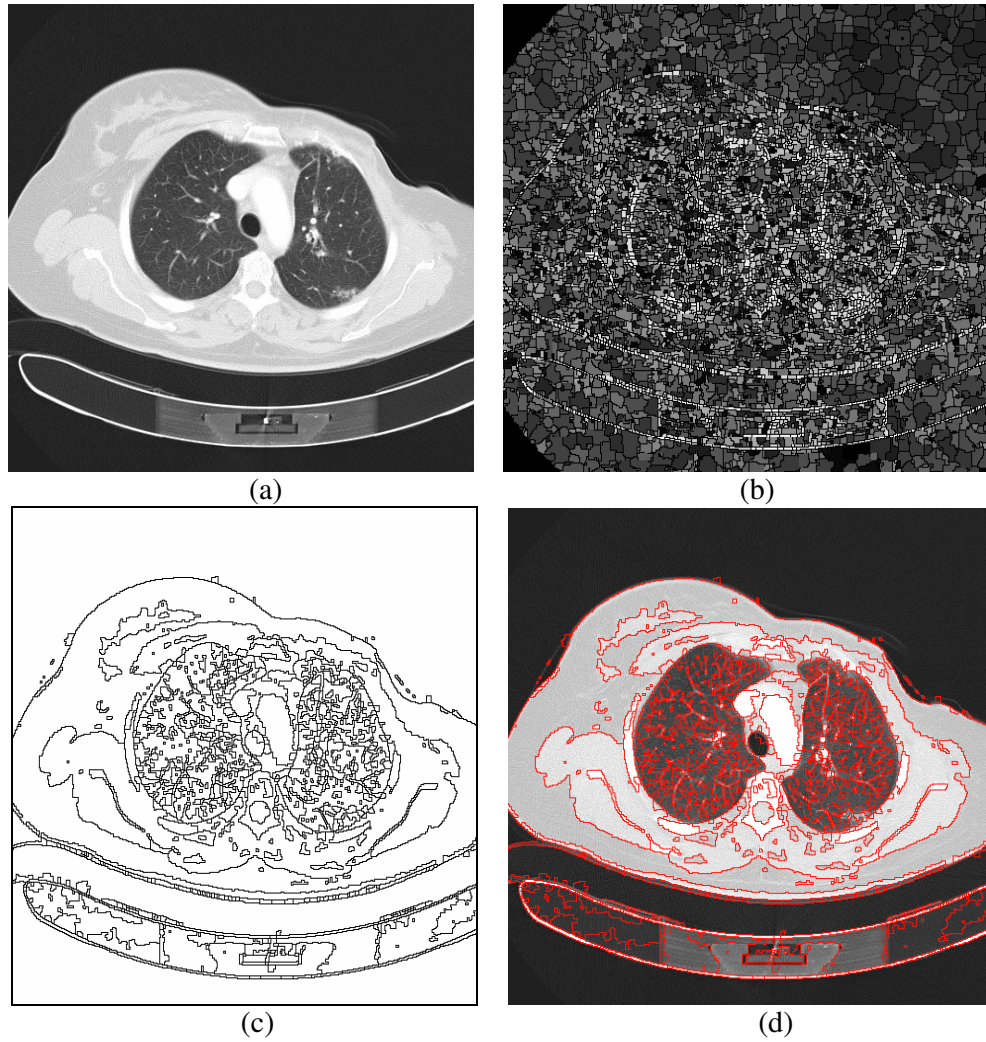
Result of Algorithm-1 for CT image. (a) Original image, (b) watershed transformed image, (c) result of region merging with Ward's Criterion (d) original image overlapped with the watershed lines
